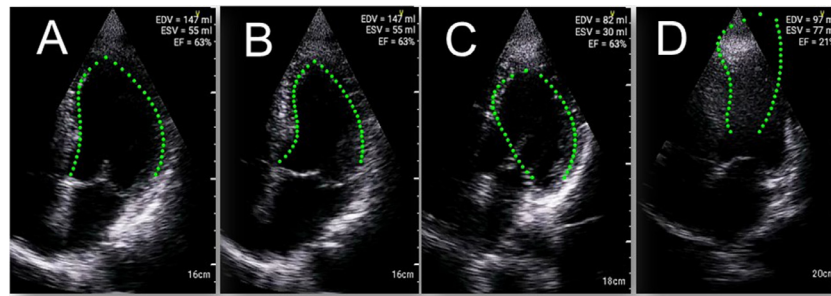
Four-chamber apical views acquired with use of handheld ultrasound devices. (a, b) Left ventricular ejection fraction measurements with LVivo software in (a) diastole and (b) systole), with good tracing of the endocardium. (c, d) Examples of LVivo software failure in endocardial border detection: (c) the entire septal endocardium border was traced incorrectly; (d) the highlighted endocardial borders do not match the actual outline of this structure.
